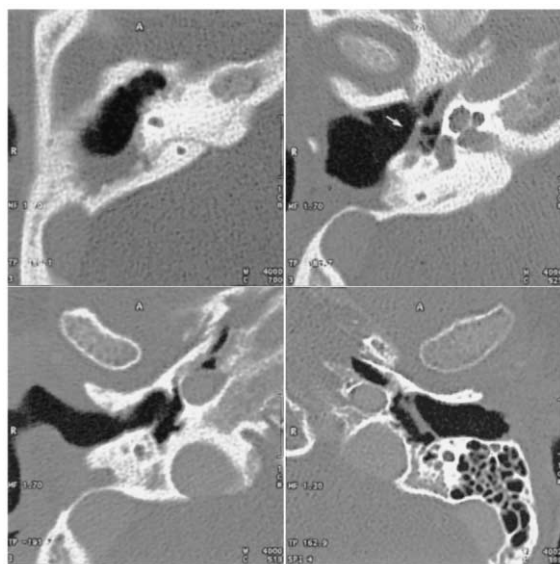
Upper lines, lower line left: a patient with open cavity and tympanoplasty type III because of cholesteatoma. Three axial CT scans show completely resected mastoid, resected posterior wall of external auditory canal and peripheral scar tissue. Incus and malleus were resected. The tympanic membrane was connected to the stapes (arrow). Lower line right: a patient after tympanoplasty type I. Axial CT shows a thickened double-layered tympanic membrane. Incidental finding.
